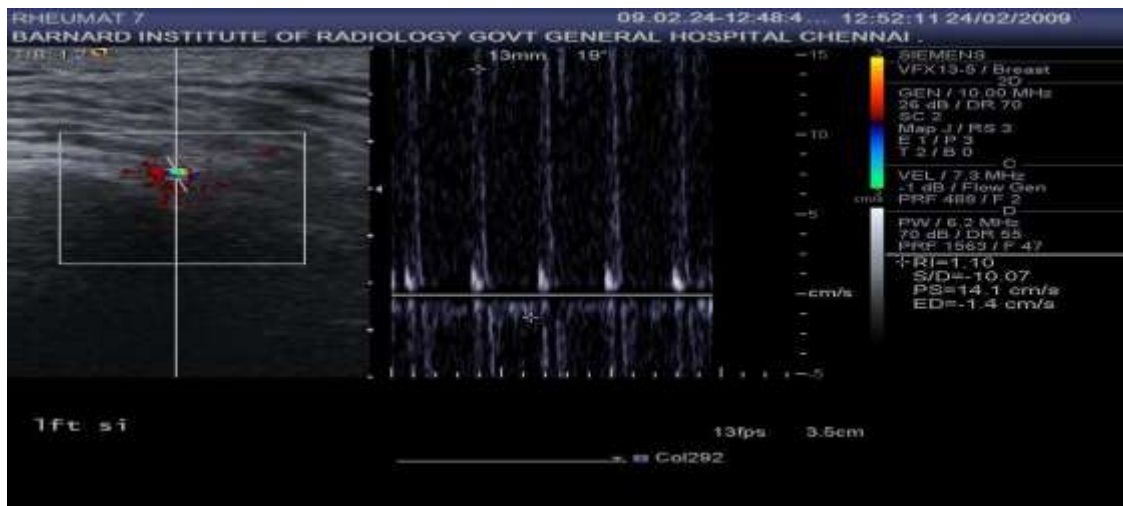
Left SIJ Power Doppler showing inflammatory flow signal with RI= 1.10 (Resistive Index)
